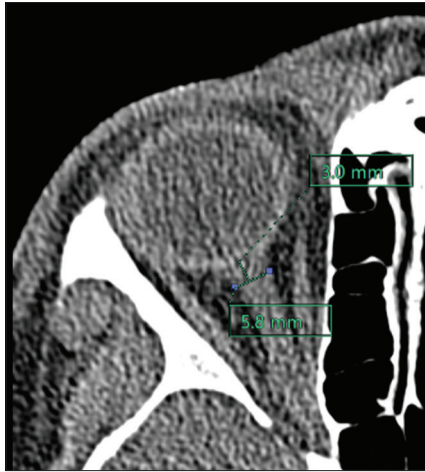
Computed tomography image showing standard protocol of measuring optic nerve sheath diameter in axial plane 3 mm behind posterior limit of eyeball in soft-tissue window
